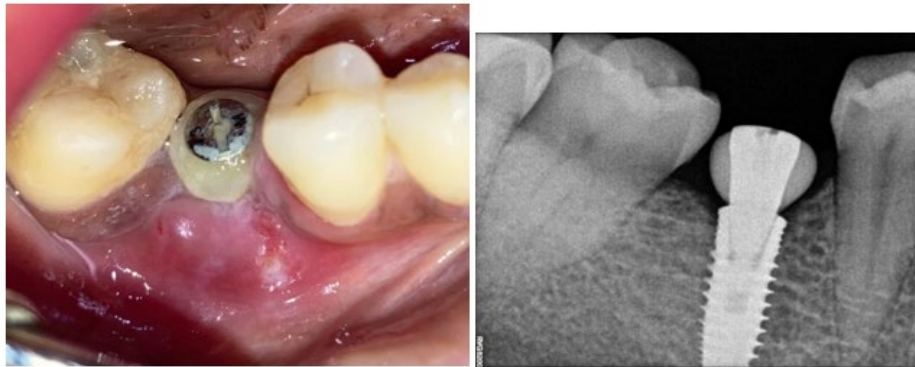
After 10 days, soft tissue healing is evaluated clinically and bone level is evaluated radiographically.
